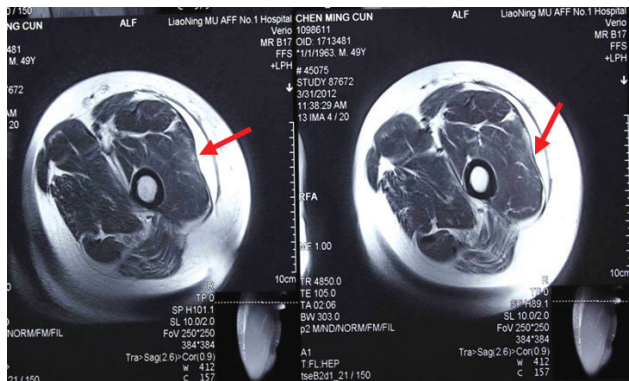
Axial MRI view showing a well defined crescentic fluid collection extending along the superficial fascia. Images show an encapsulated subcutaneous fluid collection, with a fluid-fluid level suggestive of Morell Lavallee Lesion.
